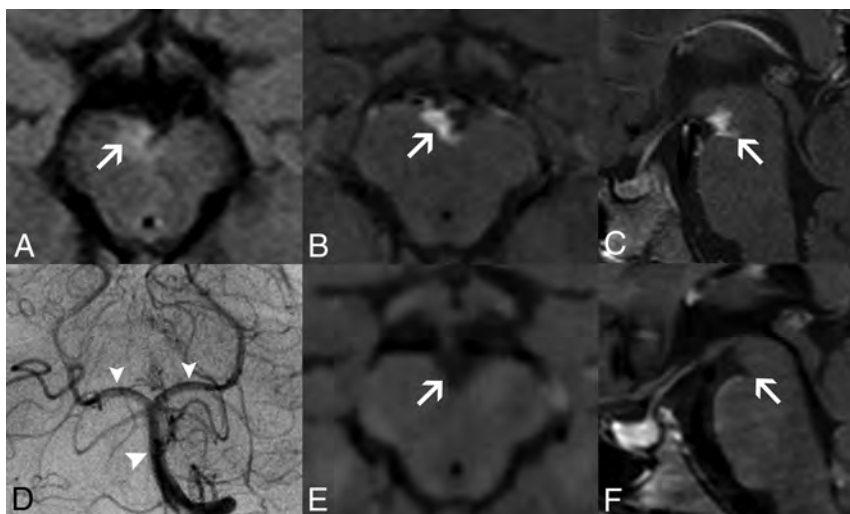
Perivascular enhancing tissue in adenosine deaminase 2 deficiency. Brain MR imaging in patient 1 at 8.5 years of age (A–D) demonstrates a soft tissue component mass in the interpeduncular cistern surrounding the basilar artery and its terminal perforator branches with eccentric vessel wall involvement. The lesion is mildly hyperintense on axial FLAIR (A, arrow), with intense solid enhancement on fat-saturated postgadolinium axial (B) and sagittal (C) T1WI sequences (arrows). DSA (D) reveals normal caliber of the basilar artery and posterior cerebral arteries (arrowheads). Postgadolinium axial (E) and sagittal (F) black-blood T1-weighted images performed at 9.7 years of age, after introduction of anti-TNF treatment, demonstrate a complete resolution of this likely inflammatory perivascular tissue (arrows).
